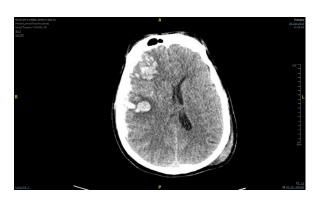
CT Scan of the brain on admission
